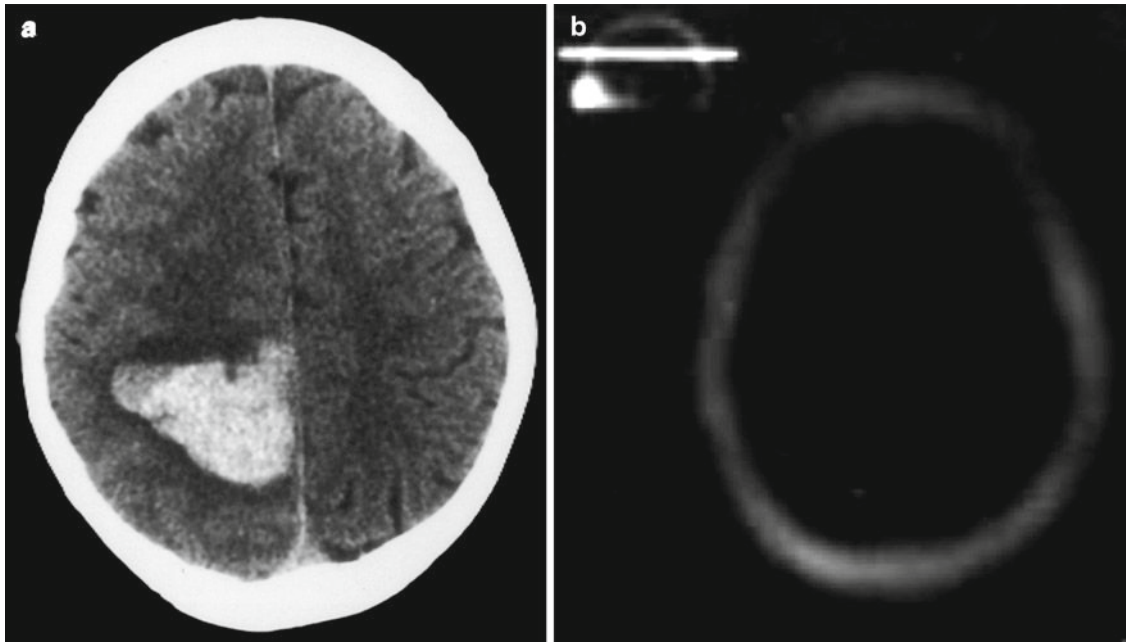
(a) Emergency CT scan in a patient with sudden onset of headache and mild left hemiparesis, showing an atypically located brain hematoma in a 42-year old male patient. (b)  $^{99m}\text{Tc}$ -MIBI SPECT, obtained within 2 days from the symptoms onset, shows no areas of pathological MIBI accumulation. The lesion was thought to be a benign hematoma. Two years follow-up confirmed this hypothesis
